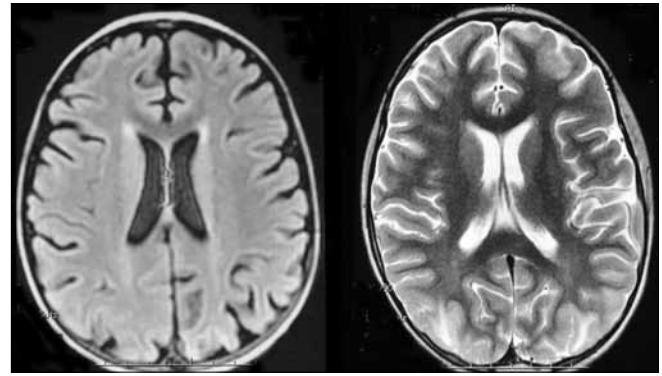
(a, b) Axial magnetic resonance image at day 15, showing almost complete resolution of the bilateral parietooccipital and left frontal lobe lesions
